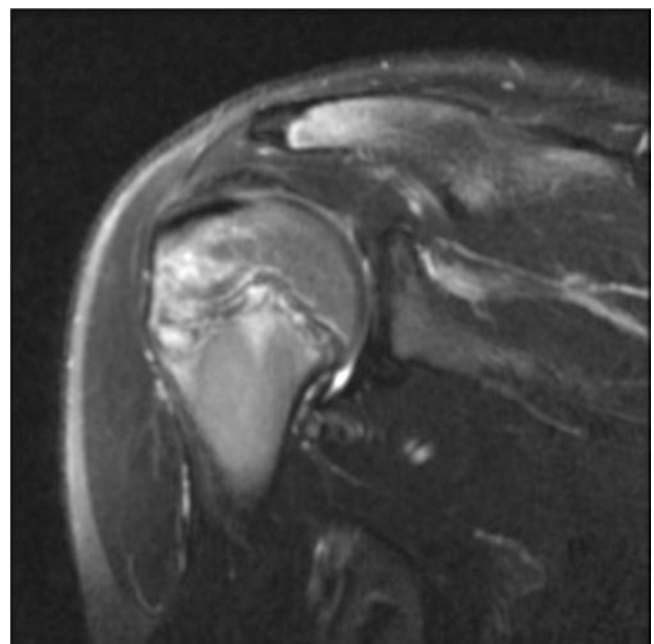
Coronal T2 MRI image demonstrating periphyseal stress fracture of the proximal humerus
